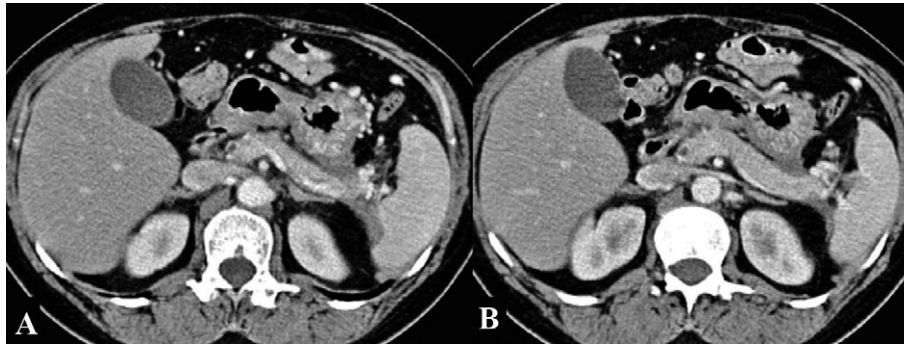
Postoperative CT, at one-year follow-up, revealing complete resolution of the pseudocyst.
